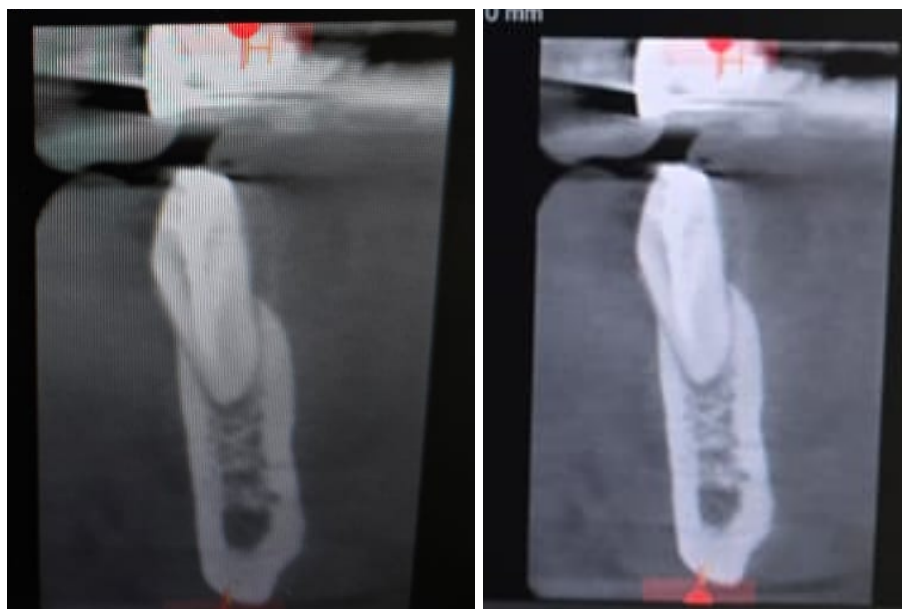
The initial CBCT.
